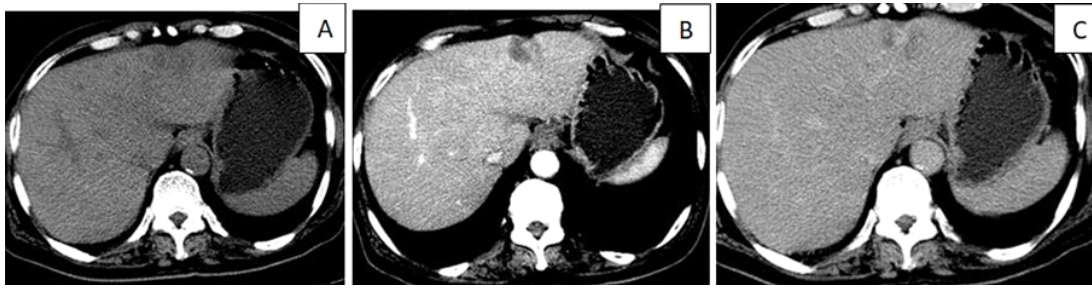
Plain and CECT images of liver lesion (metastasis) in a 70 year old male with carcinoma colon showed (A) hypodense lesion on plain image,(B)Peripheral rim enhancement on contrast CT and (C) hypodense lesion compared to liver parenchyma ondelayed image.
